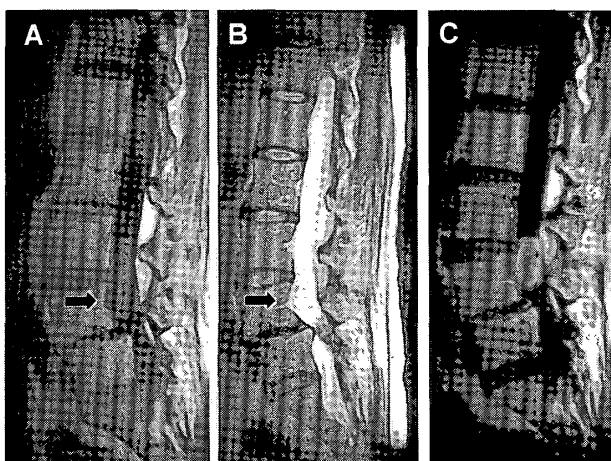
Sagittal spin-echo T1-(A) and T2-weighted (B) magnetic resonance images revealing the iso intensity tumor on T1 and high intensity on T2. The tumor was enhanced by gadolinium-diethylenetriaminepenta-acetic acid (C).
